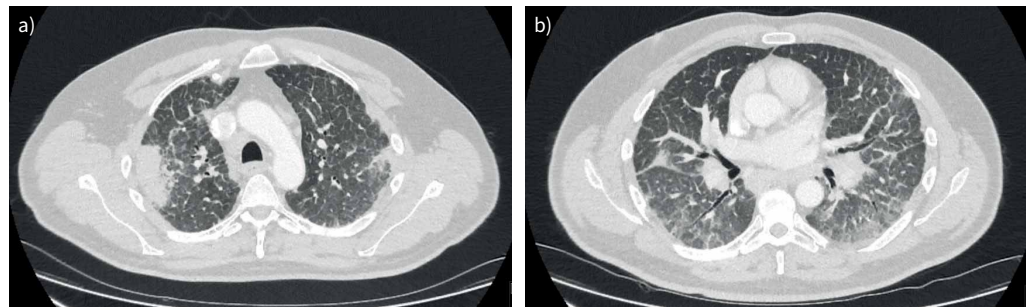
High-resolution computed tomography showing mediastinal and hilar lymphadenopathy, upper zone dense bilateral subpleural opacities and reticulation extending towards the periphery. a, b) Different cross sections.
